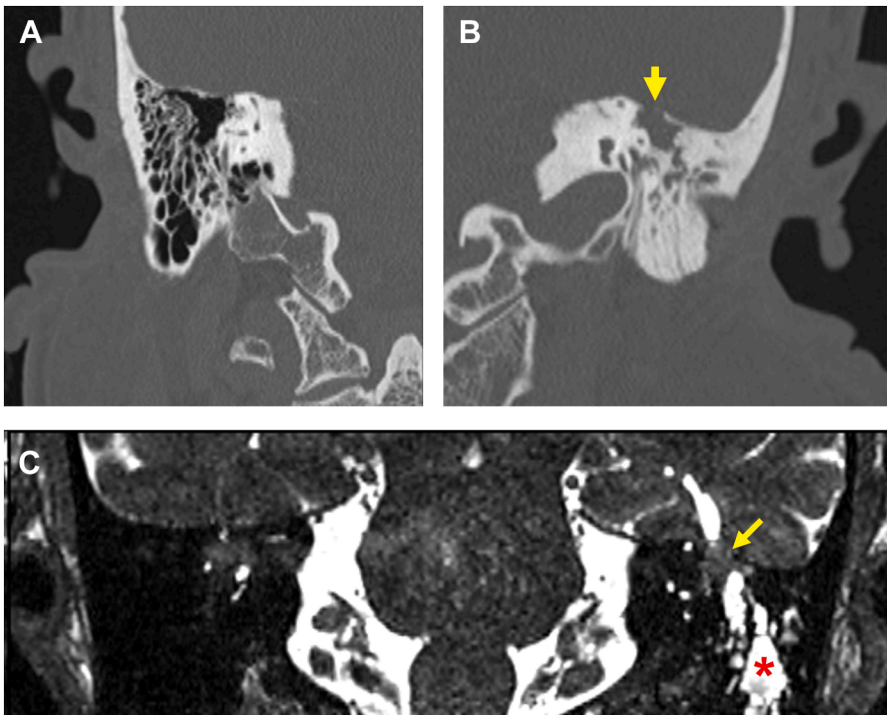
Tegmen dehiscence and temporal lobe encephalocele. (A) Normal high-resolution computed tomography (CT) of right temporal bone (coronal view). (B) Dehiscence of tegmen tympanicum (*yellow arrow*) on coronal CT of left temporal bone. (C) Coronal T2-weighted constructive interference in steady state (CISS) sequence on magnetic resonance imaging showing isointense brain herniation (or encephalocele) into temporal bone (*yellow arrow*) and associated hyperintense CSF in mastoid air cells (*).
